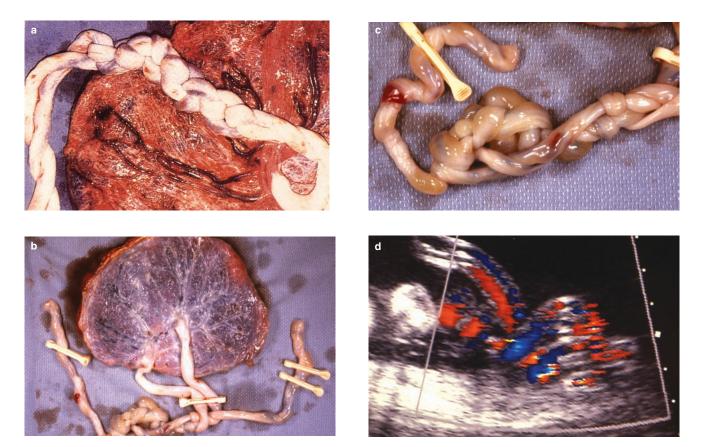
Almost all monochorionic–monoamniotic (MC–MA) twins have entwined, braided and/or knotted cords. (a) These twins survived intact. (b) Both twin fetuses in this case died from cord entwining. (c) Close-up view of complex knotting and braiding. (d) Because braiding occurs in almost all MC–MA pregnancies, it should be looked for in the ultrasound examination, especially in cases where the membranous septum is thin and it is not clear whether the twins are diamniotic (DA) or MA
